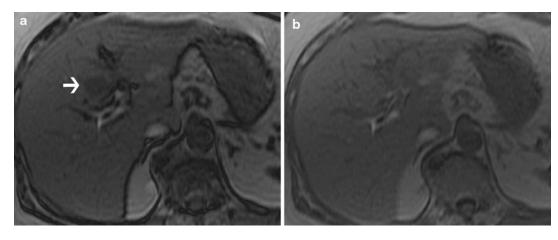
A focal fat. A 65-year-old woman with history of lymphoma. MRI was performed to characterize a liver mass adjacent to porta hepatis seen on surveillance CT scan (not shown). Axial, out-of-phase T1-weighted
